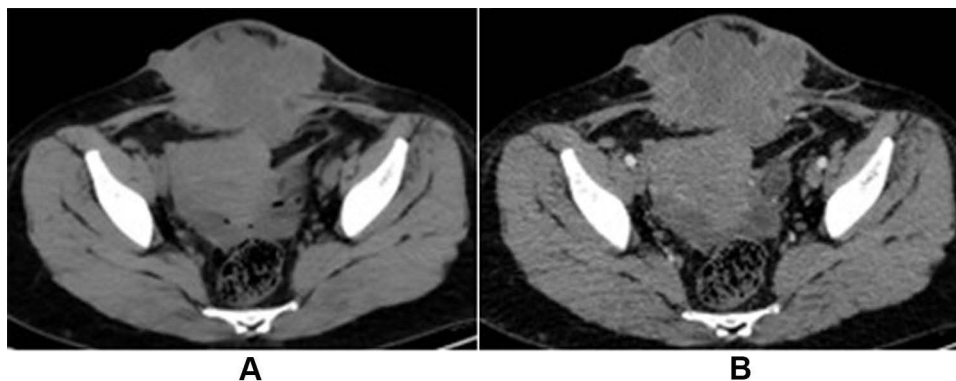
CT image of the abdominal mass shows a heterogeneous tumor associated with cesarean section scar: plain scan (A) and contrast enhancement (B). (A) Plain scan showed a lobulated cystic mass at the previous cesarean section scar. (B) The solid components showed mild enhancement after contrast.
